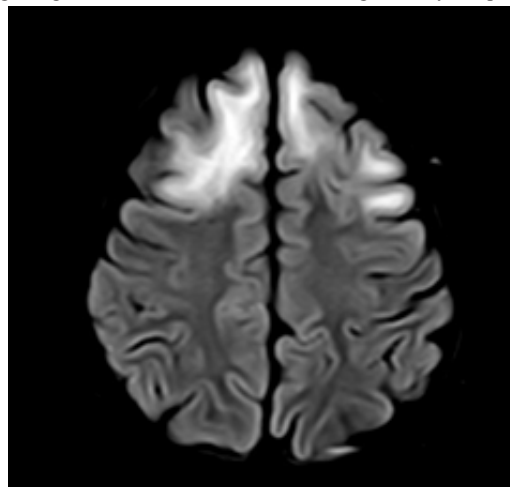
MRI showing, Axial FLAIR - confluent hyperintensity in the bilateral frontal subcortical white matter, representing cortical/white matter involvement.
